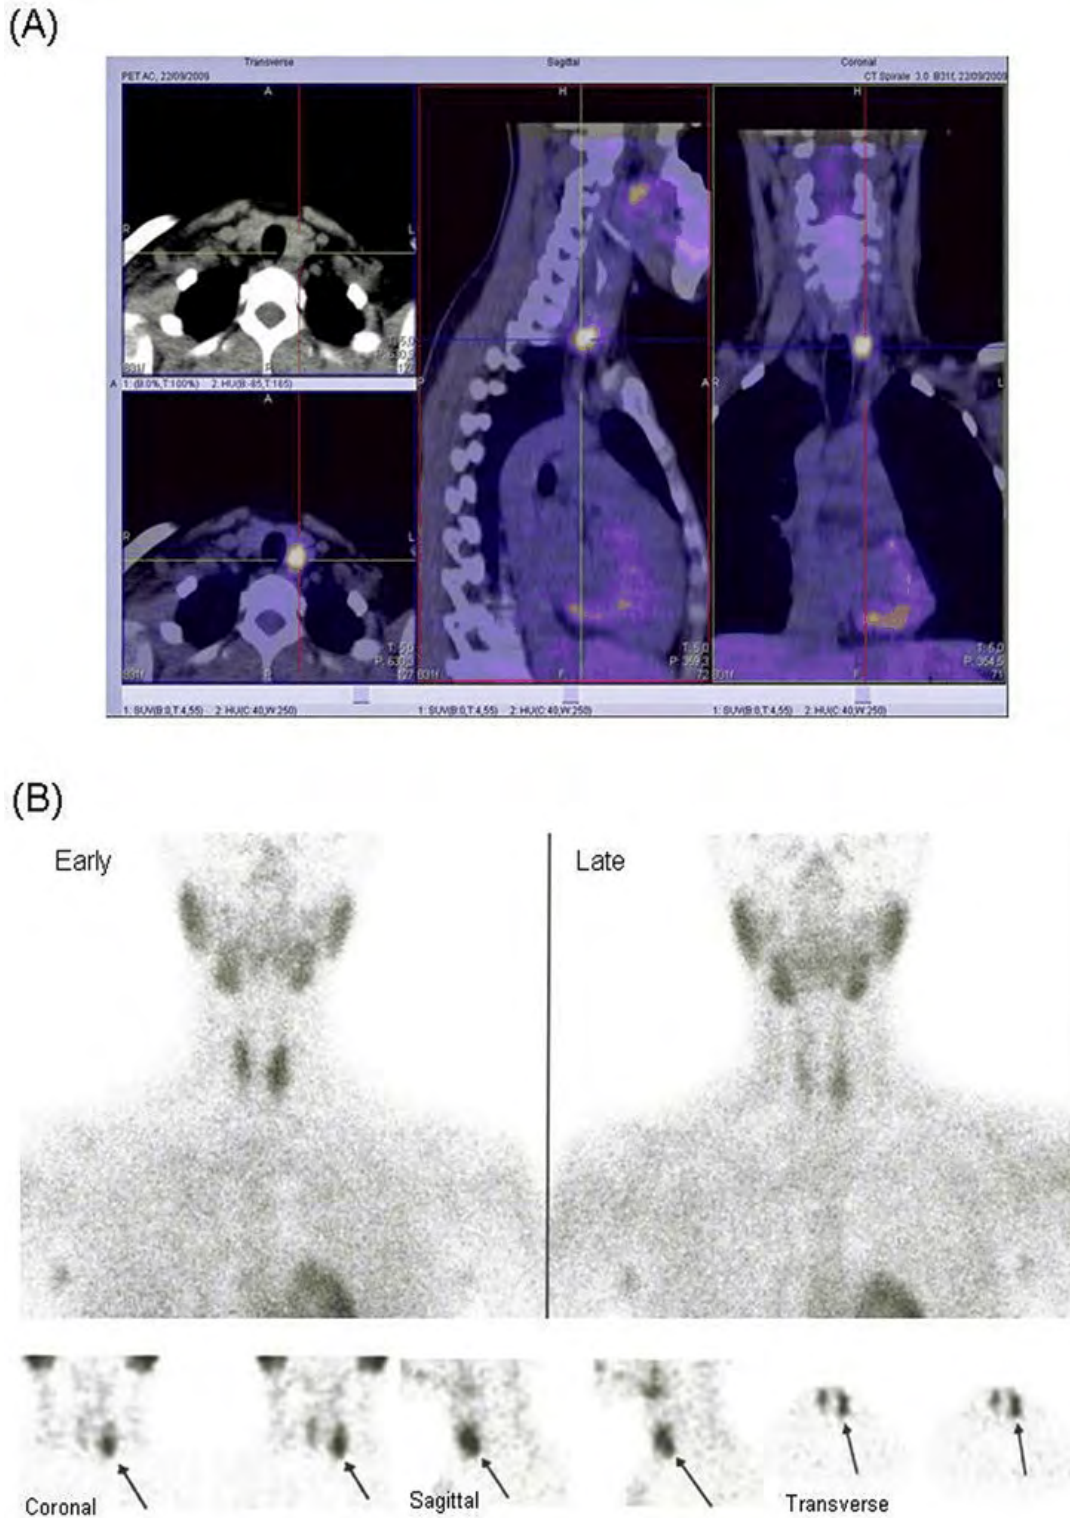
(A) PET/CT image with the use of ^{18}F -FDG. It shows a small area near and posterior to the left lower pole of the thyroid gland with moderate hypermetabolism. (B) Depiction of the localization of the adenoma shown by $^{99\text{m}}\text{Tc}$ -sestamibi parathyroid dual-phase scintigraphy.
